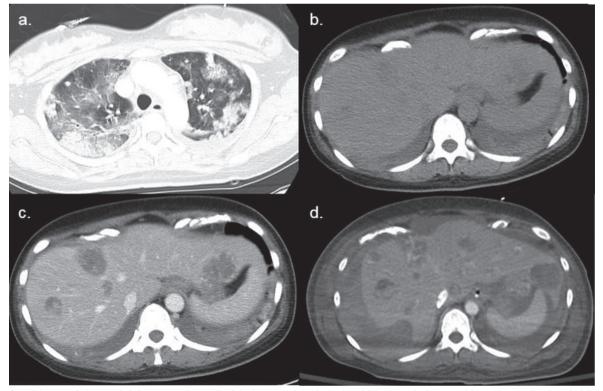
CT image of chest and abdomen. a. Chest CT of the lung window showed multiple ground-glass opacities and consolidations in bilateral lungs (1st day of admission); b. The artery phase of the liver CT (1st day of admission); c. The venous phase of the liver CT (1st day of admission). d. CT angiography of the liver showed multiple progressive hypervascular liver tumors with rupture, leading to subcapsular hematoma and hemoperitoneum (13th day of admission).
